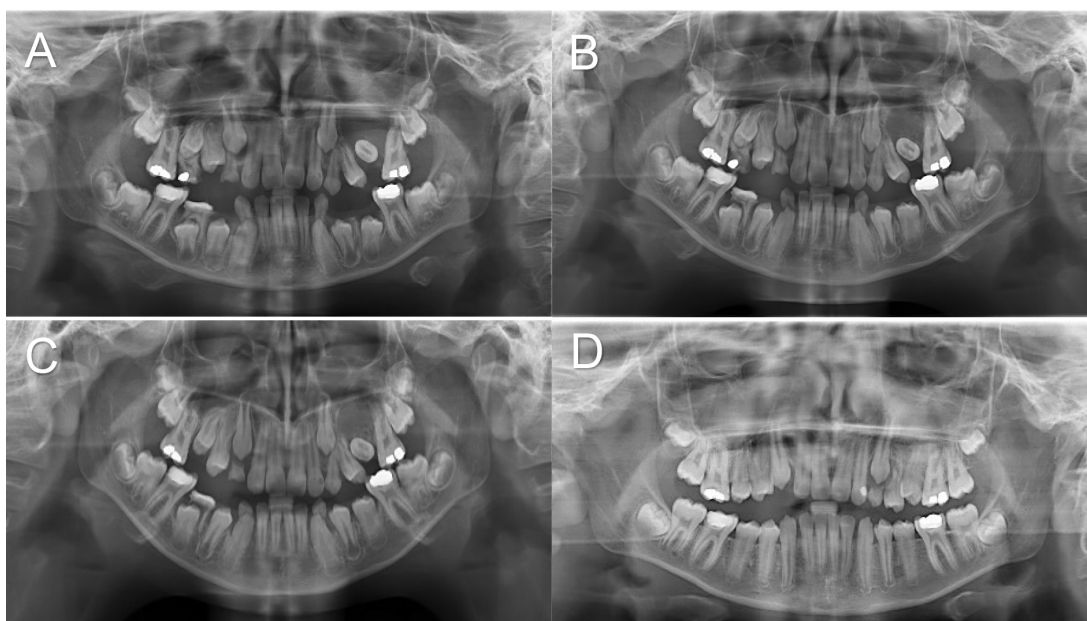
Case 2: panoramic radiographic findings during treatment. (A) Pre-operative. (B) Post-operative 3-month follow-up. (C) Post-operative 6-month follow-up. (D) Post-operative 12-month follow-up.
